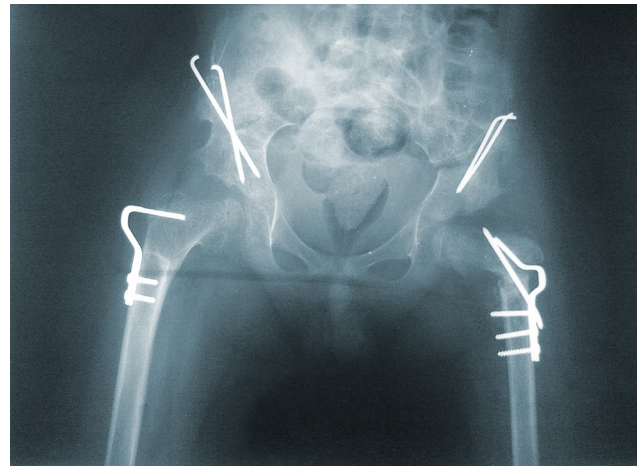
Standing anteroposterior radiograph showing the pelvis after Salter's pelvic osteotomy, femoral shortening, and intertrochanteric derotation osteotomy.
